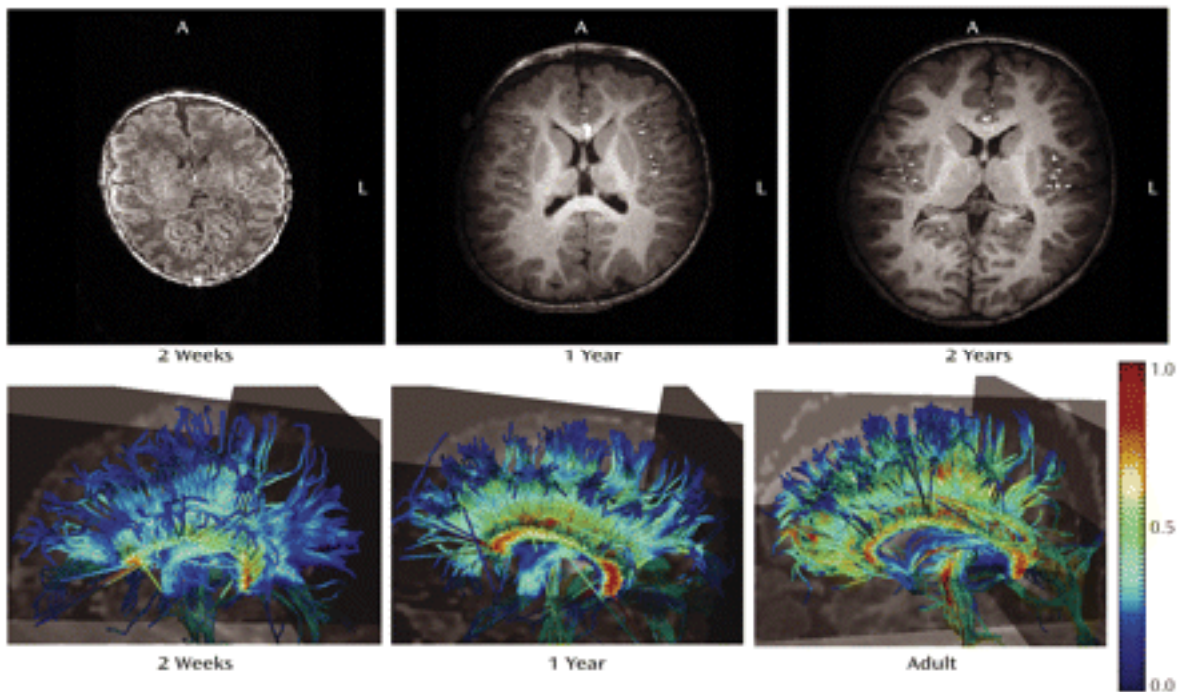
MR imaging of corpus callosum development⁸
